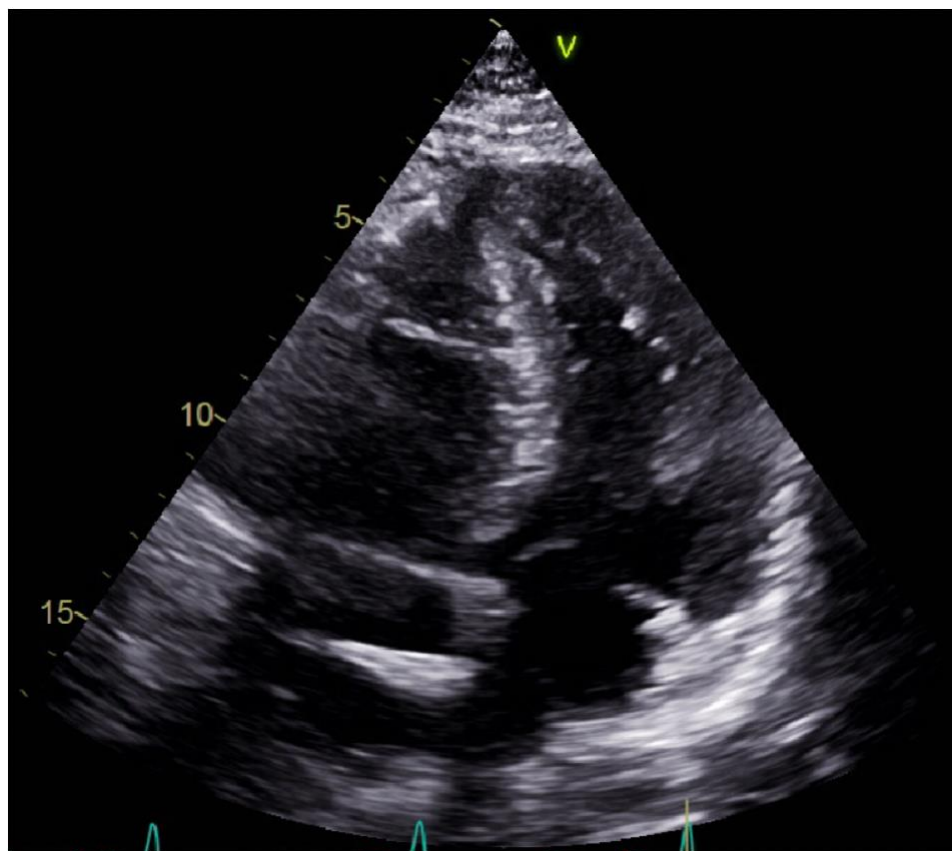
Echocardiogram prior to discharge demonstrating improved left ventricular systolic function after removal of bilateral impella ventricular support devices, LVEF approximately 55%.
